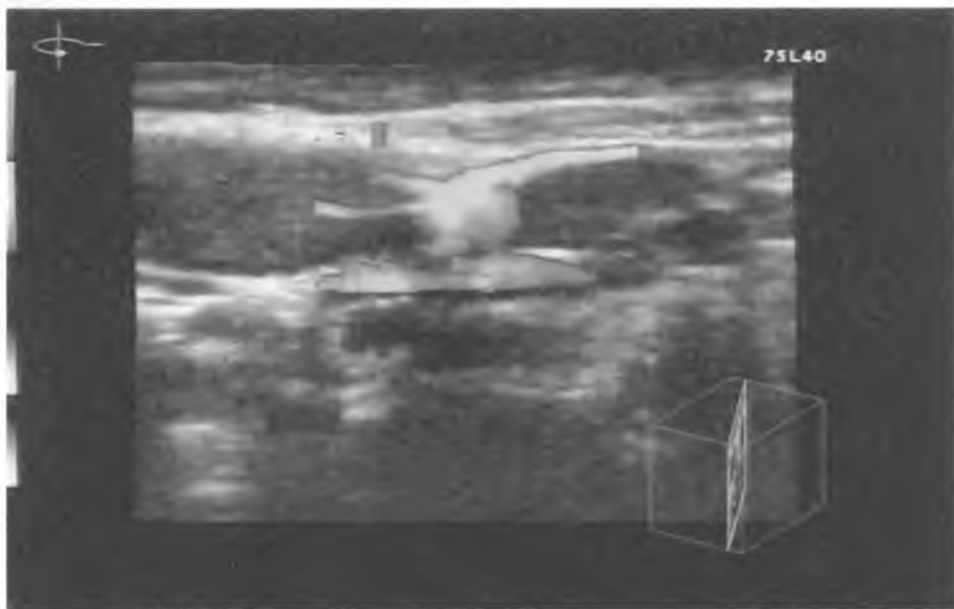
The lymph node from Figure 5. Power Doppler mode, 3D presentation. With the use of other dimension in 3D mode. Visualisation of 3 additional branches of the main vessel
